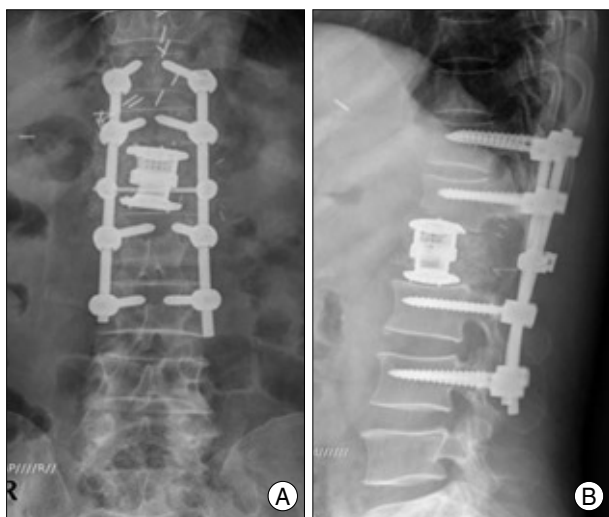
Postoperative AP (A) and lateral (B) X-ray showing L1 body replacement with an expandable cage after total en bloc spondylectomy.
